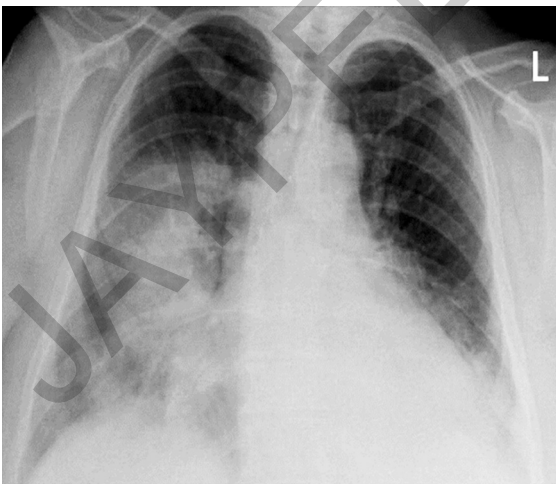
X-ray findings—minimal loss of volume with lobar distribution and homogeneous density (whiter area) late in the consolidation process.
